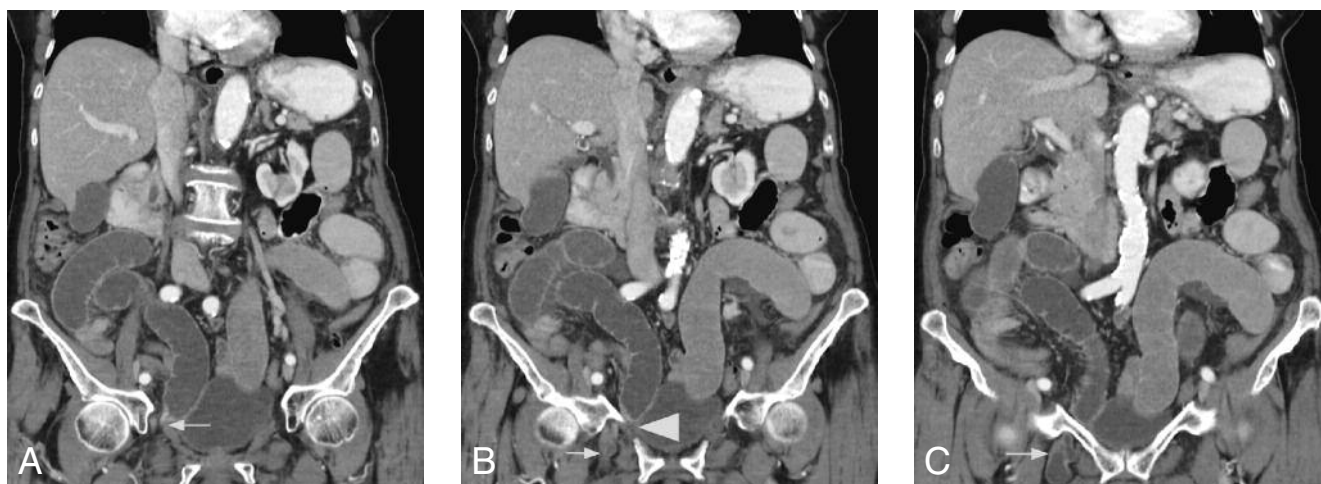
Reconstructed coronal CT image (A) shows multiple dilated small bowel loops and level of herniated small bowel through the obturator canal (white arrow). B shows multiple dilated small bowel loops and herniated small bowel (white arrow) inferior to the right ramus pubis inferior (arrowhead). C. shows multiple dilated small bowel loops and herniated small bowel (white arrow) inferior to the right ramus pubis inferior.
